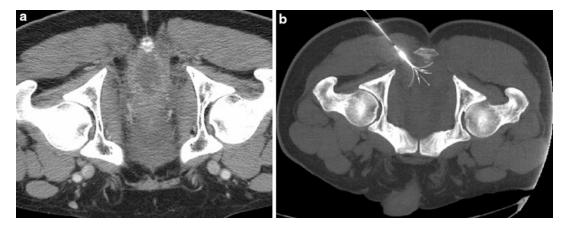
Metastatic presacral rectal carcinoma. (a) Prone contrast-enhanced CT demonstrates a peripherally enhancing soft tissue mass anterior to the coccyx. (b) Prone CT demonstrates the RF ablation electrode deployed within the mass. Patient's pain decreased from 8/10 to 1/10 four weeks posttreatment. The patient continues to report 0–1/10 pain at this site 24 months
